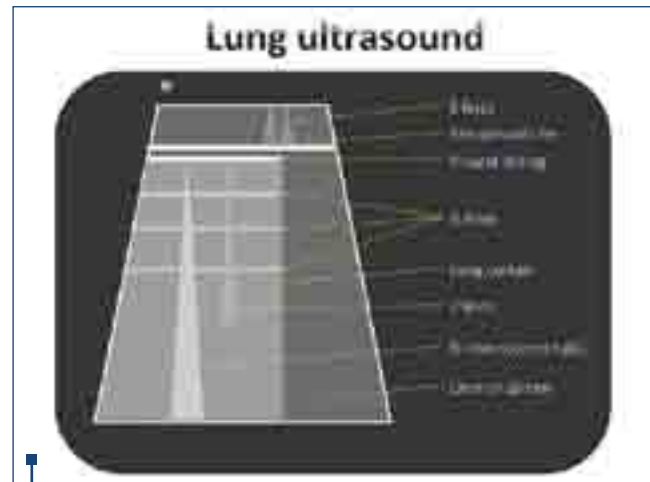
Most common signs and artefacts on thoracic ultrasound
